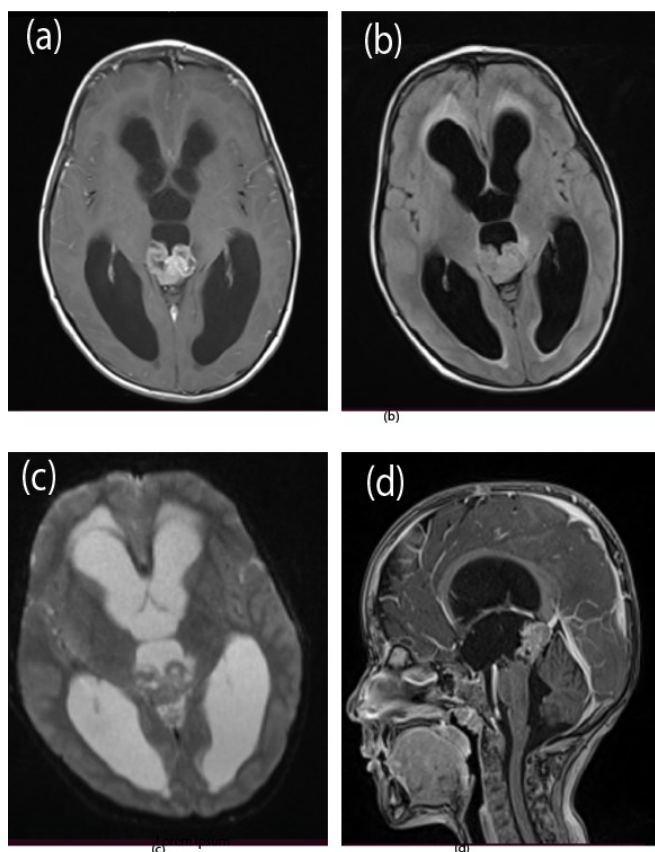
Pre-Operative MRI, (a): T1 Post Contrast, (b) FLAIR, (c) Diffusion Weighted Series, (d) Sagittal View T1 Post Contrast.
